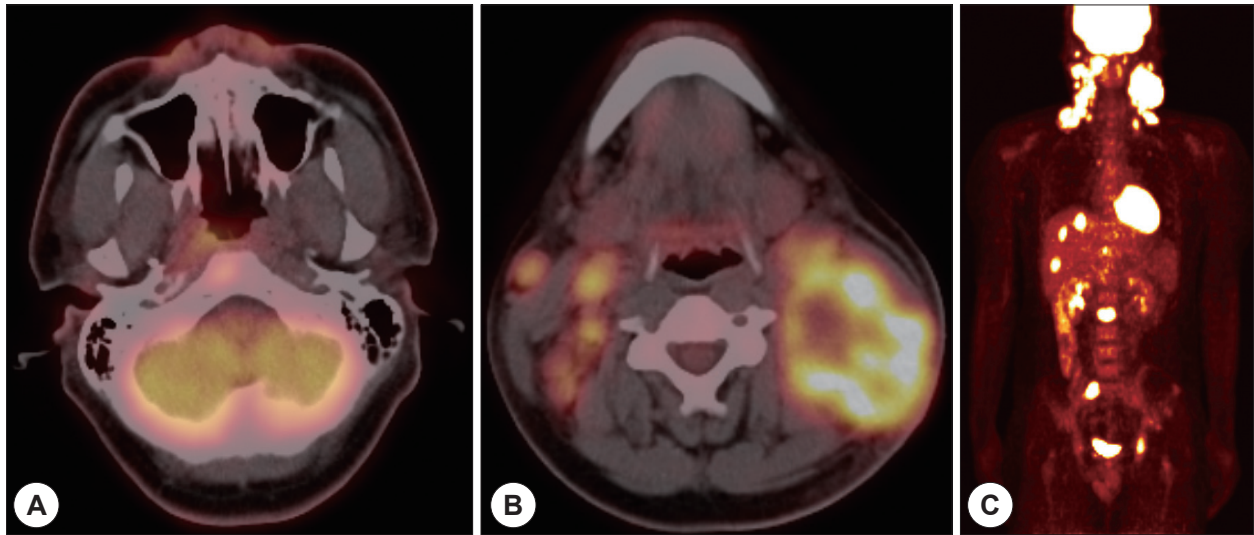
Fluorine-18 fluorodeoxyglucose(F-18 FDG) at positron emission tomography(PET)/Computed tomography scan at diagnosis. Abnormal F-18 FDG uptakes in the right nasopharynx(A), neck nodes(B) and distant organs(C) were observed.
